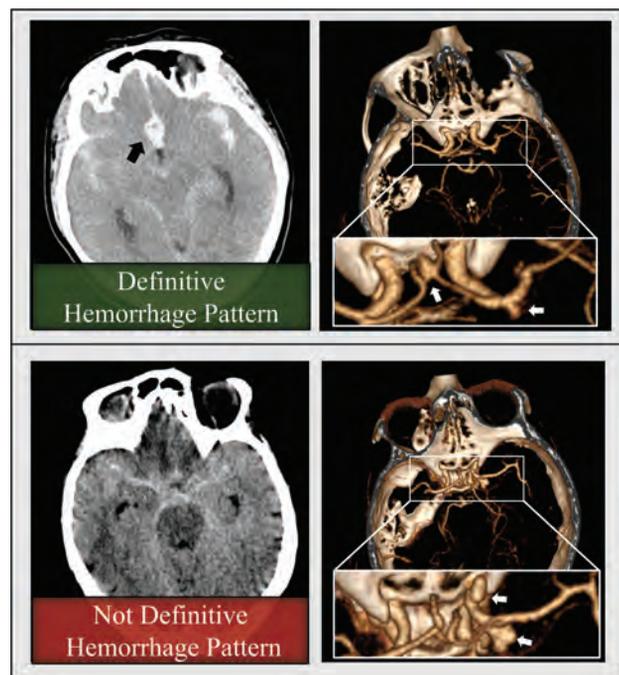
Top, A 62-year-old woman who presented with SAH (left image, noncontrast CT scan) was found to have anterior communicating artery and MCA aneurysms (white arrows, right image, CTA). A focal hematoma in the anterior circulation (black arrow, left image) delineated the anterior communicating artery aneurysm as the source of bleeding, which was confirmed at surgery. Bottom, A 59-year-old woman presented with SAH (left image, noncontrast CT scan). She was found to have 2 large lobulated right ICA aneurysms (white arrows, right image, CTA). The source of the rupture could not be identified from the hemorrhage pattern (this patient was excluded from our study). Both aneurysms were treated endovascularly.
